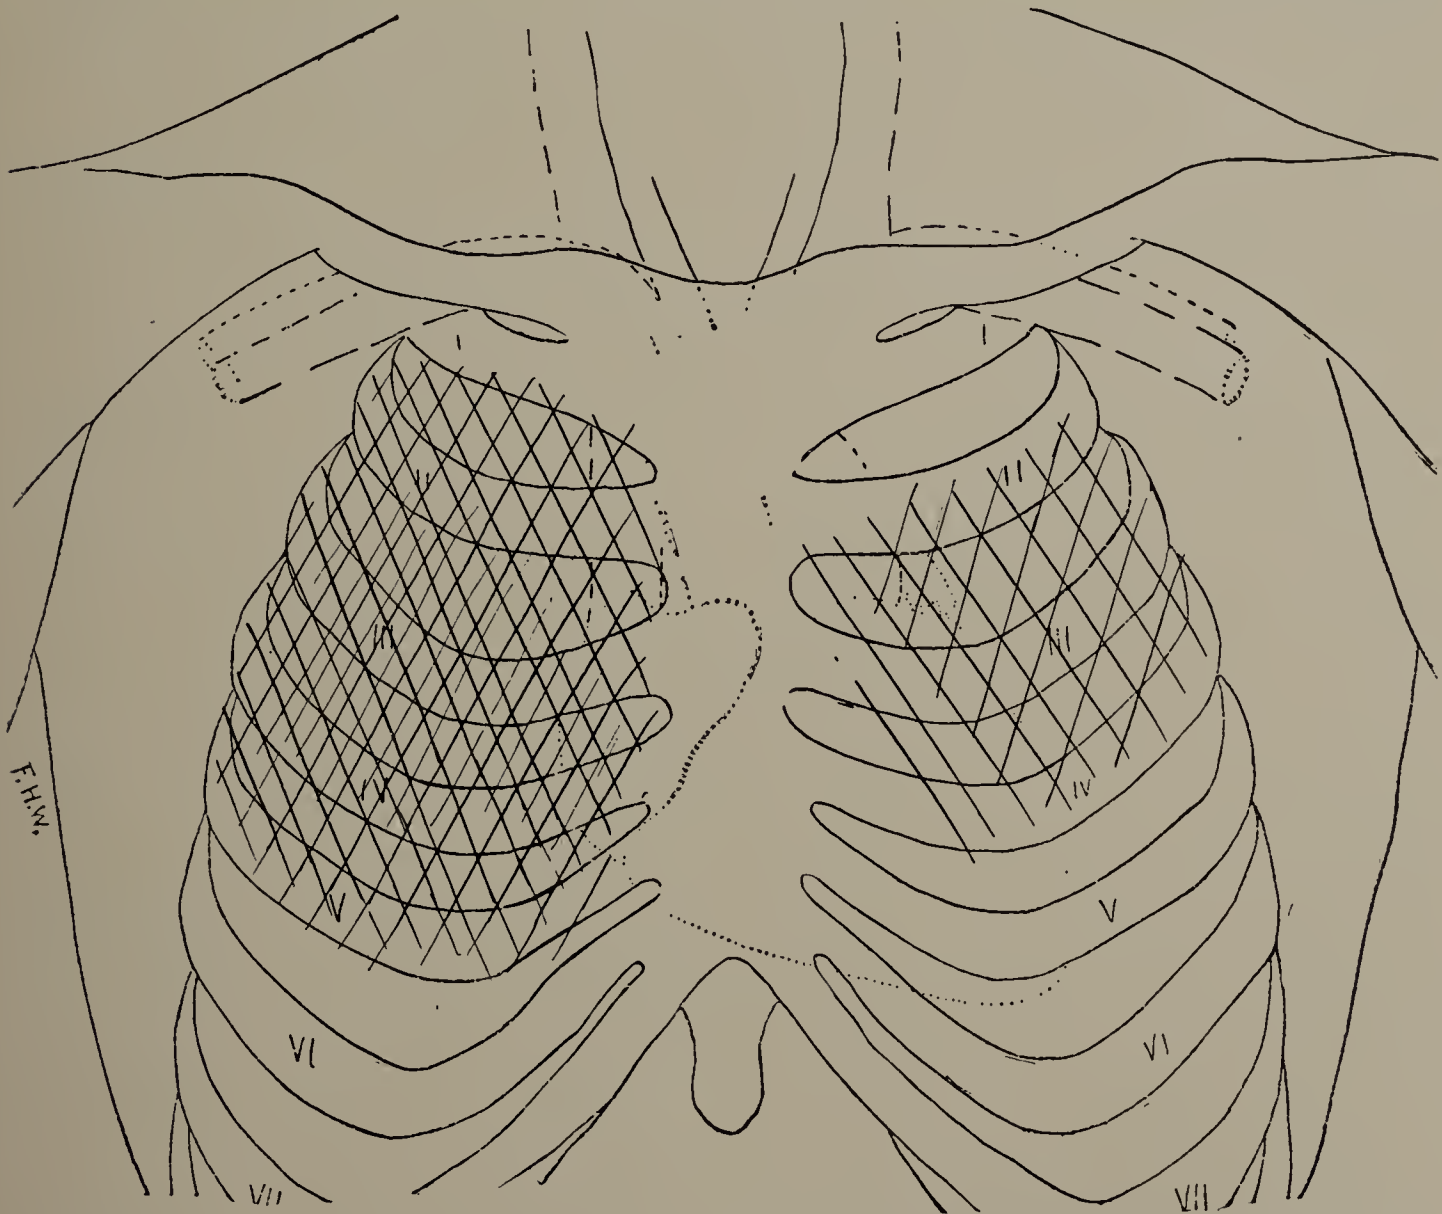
G. R. Second X-ray examination with screen. Patient improving. Excursion of diaphragm 1.25 centimetres on right side; increased on left side. (One-third life size.)
